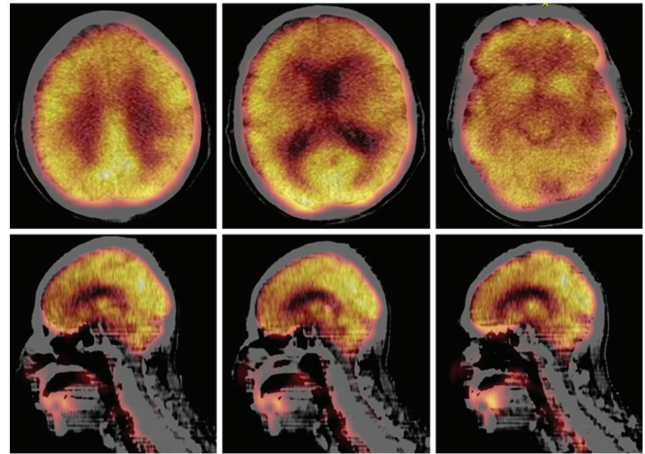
Cranial FDG-PET/CT fusion images of a 59-year-old male patient (top row: transaxial sections from the vertex towards inferior; bottom row: sagittal sections): Frontal cortex FDG uptake appears to be decreased (Frontal cortex SUVmean $r = 0.68$). HADS-A and HADS-D scores were found 12 and 9, respectively.
